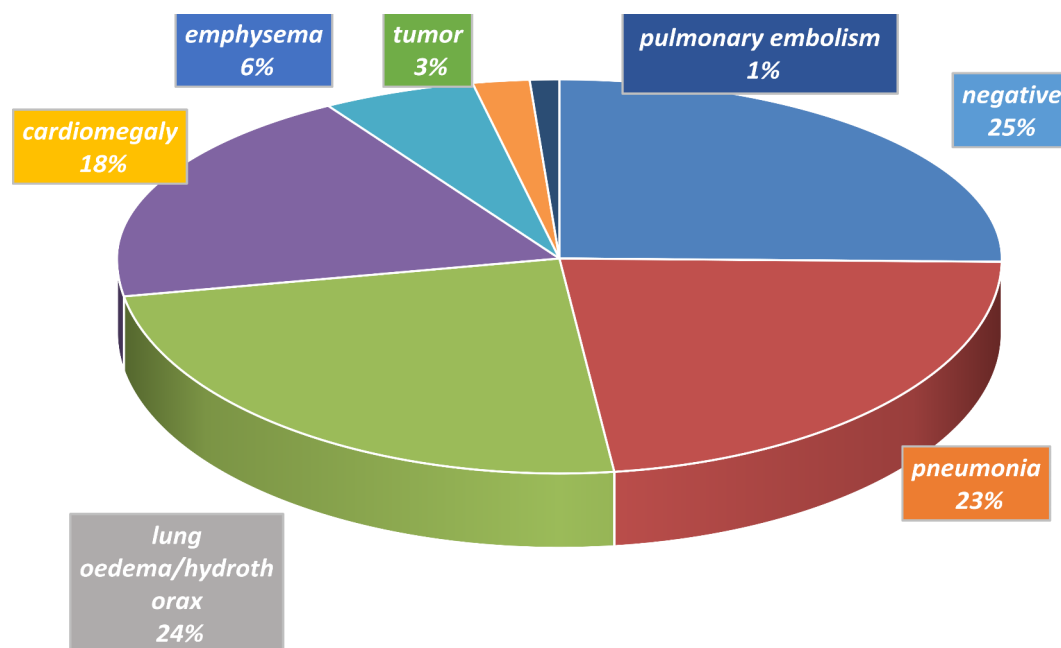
Findings of the chest CT examinations in the whole cohort.
